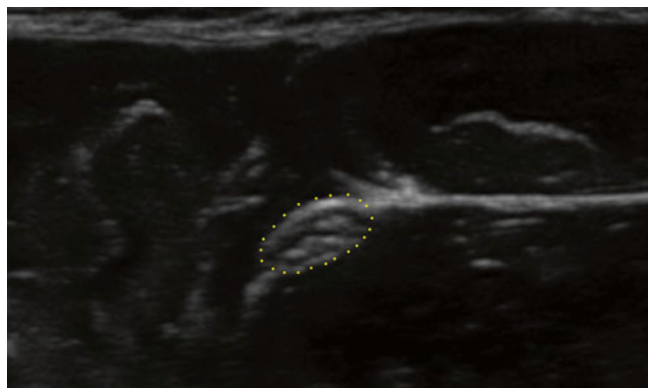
Cross-sectional (*short axis*) ultrasound image (Image courtesy of Andrea Trescot, MD)
